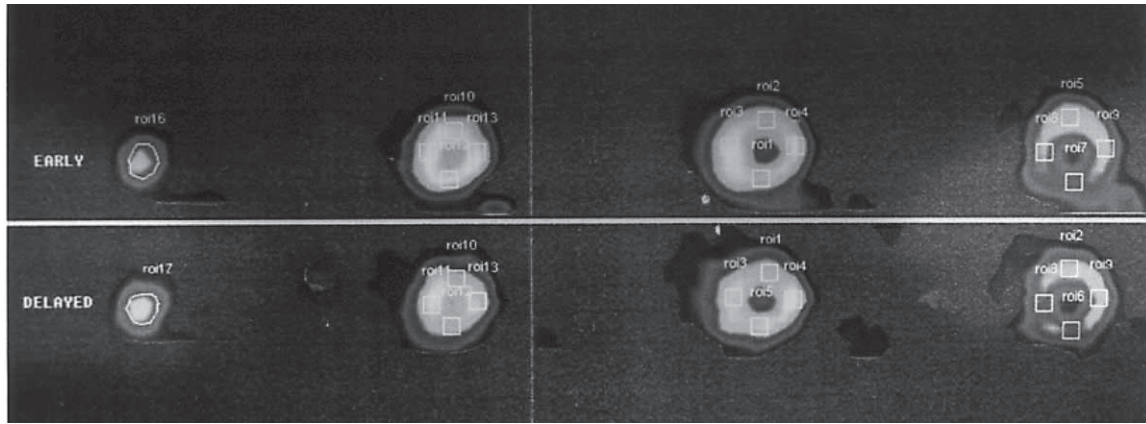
Early and delayed short-axis SPECT images with regions of interest.
